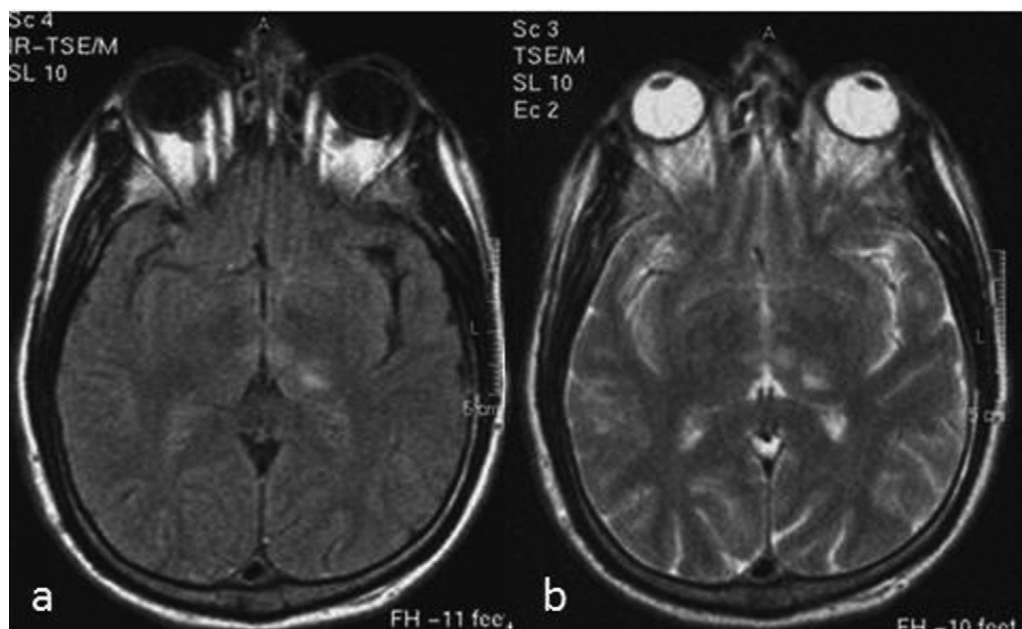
MRI in T1 (a) and T2 (b) sequence disclosing acute bilateral paramedian thalamic infarct.
